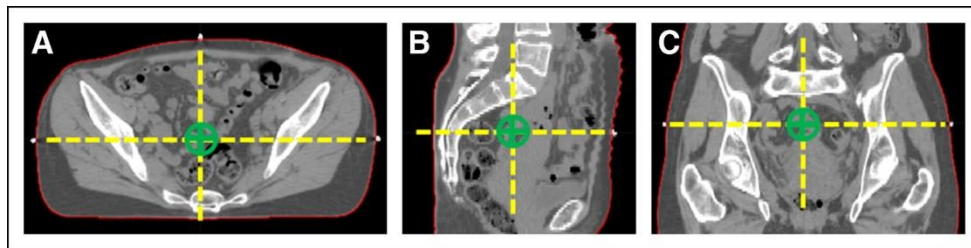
Body contour and marked isocenter. (A-C) Three views, (A) axial, (B) sagittal, and (C) coronal, of the computed tomography scan of a patient. The automatically segmented body contour is outlined in red. The views intersect at the location of the marked isocenter (green), which is determined on the basis of the radiopaque external fiducials. The intersecting planes are denoted by the dashed yellow line.
